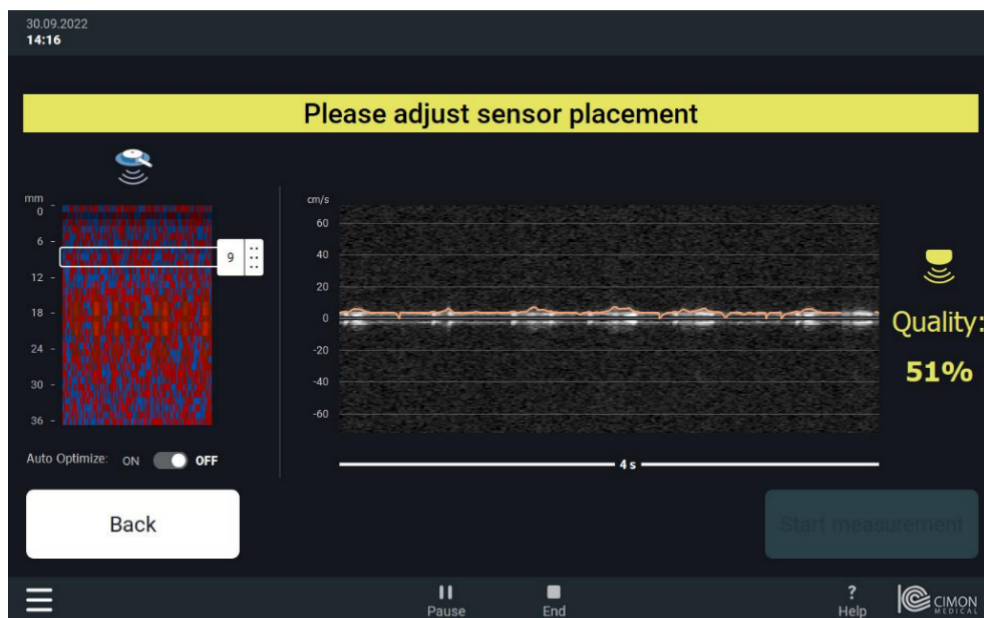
NeoDoppler depth selection interface. Taken from the NeoDoppler manual [31]
